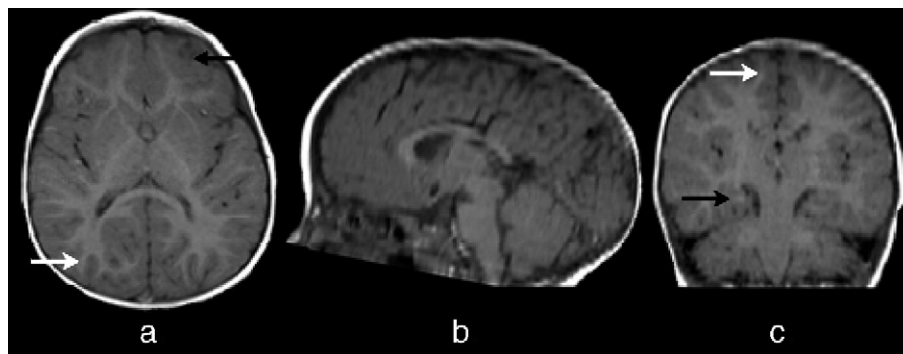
T1-weighted structural MR images from a toddler (female) at 18 months of age (1:6). (a) Axial image oriented parallel to the anterior/posterior commissure line at the level of the Foramen of Monro and the basal ganglia. (b) Sagittal and (c) coronal images obtained by reformation from the axial images centered on the brainstem. Note that by 18 months of age, the gray/white matter contrast in the parietal lobes has already attained the adult-like pattern (white arrows). An immature pattern of myelination is noted in the subcortical regions of the frontal lobe and in the mesial temporal lobes (black arrows). Note that the same child is presented in this figure and Figs. 2–7, and that radiologic convention is followed for presentation of axial and coronal images in which the left side of the image corresponds to the right side of the participant.
